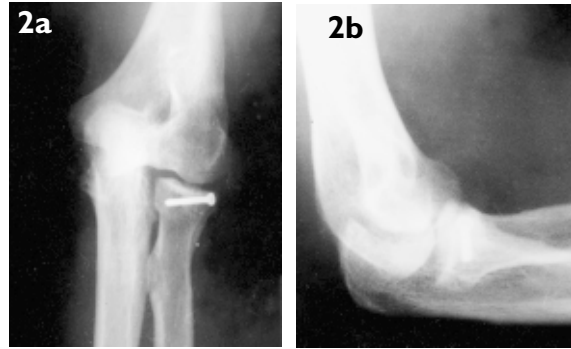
Case 7. (a) AP and (b) lateral radiographs of the left elbow of a 50-year-old man taken three years after open reduction. The radial head fracture, Mason type II, was fixed with a screw. There is suggestion of subluxation of the elbow.
